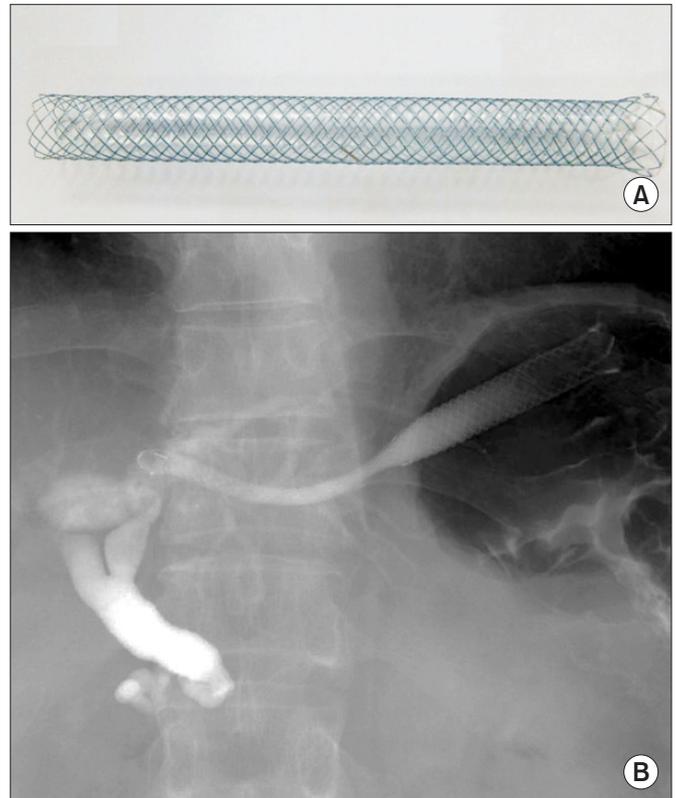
Endosonography-guided hepaticogastrostomy using a long, partially covered self-expandable metallic stent. (A) A Niti-S Modified GIOBOR stent (Taewoong Medical Co., Ltd., Goyang, Korea). (B) A modified GIOBOR stent (12 cm) placed from B3 to the stomach. The portion protruding into the stomach was > 60 mm in length.
